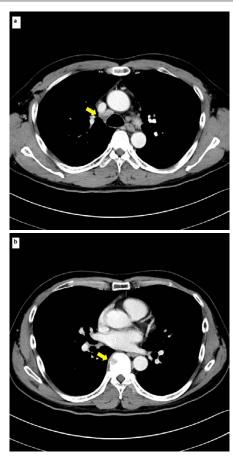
Chest CT images after treatment: (a): Contrast-enhanced CT after 4 cycles of pembrolizumab shows that the nodule in the middle mediastinum has almost disappeared; (b): Osteolytic change of Th8 has also improved.
